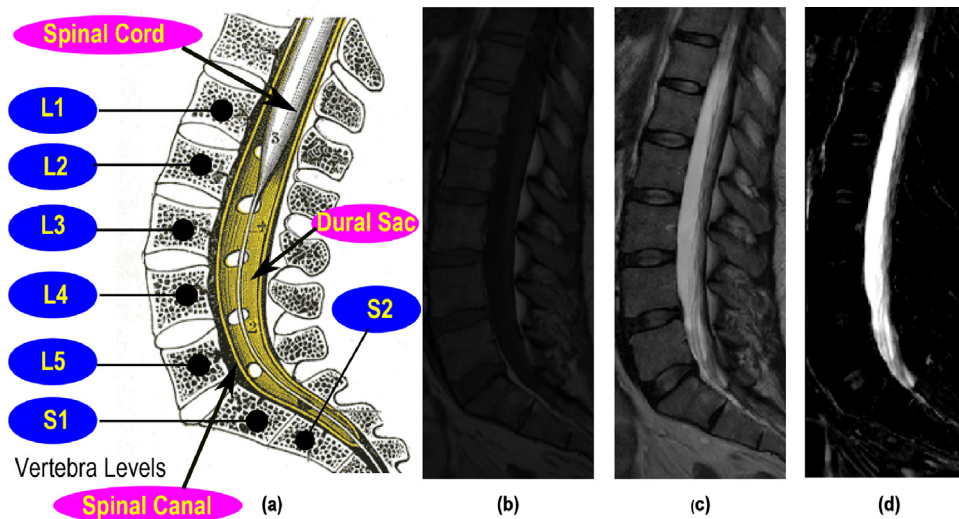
(a) Lumbar spinal anatomy [13], (b) a T1-weighted sagittal image, (c) T2-weighted sagittal image, and (d) an image formed by intensity difference between the T1-weighted image and the T2-weighted sagittal image. The spinal cord reaches around the level L1 where it divides into many individual nerve roots and the dural sac shielding the spinal cord terminates around the level S2. The spinal canal is the anatomic covering for the spinal cord.
